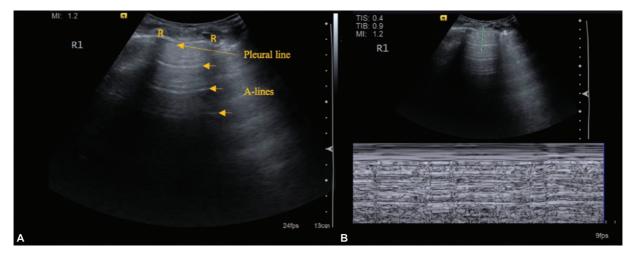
(A) Longitudinal ultrasound scan of the anterior chest wall depicting the 'Bat sign': Two ribs (R) with posterior acoustic shadowing (wings of the bat), and the hyperechoic pleural line (body of the bat). A-lines can be seen parallel to the pleural line. (B) M-mode at the same location demonstrating the 'SEASHORE SIGN'- The motionless chest above the pleural line results in the horizontal 'waves,' and the lung sliding below the pleural line generates the 'sand,' seen as a granular pattern.
